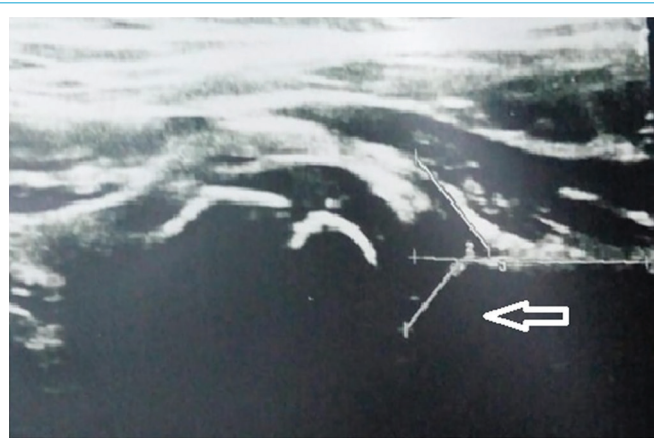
Ultrasonography image of the same pediatric patient showing narrowed iliac drift angle (Graf's alpha angle) on coronal plane.
